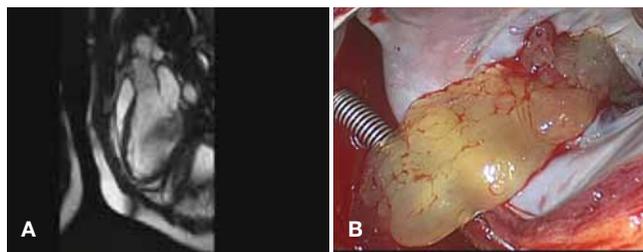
(A) MRI scan of left atrial tumor involving the mitral valve and left ventricular wall; (B) Intraoperative photo of tumor and its relationship to the left ventricle and mitral valve.
